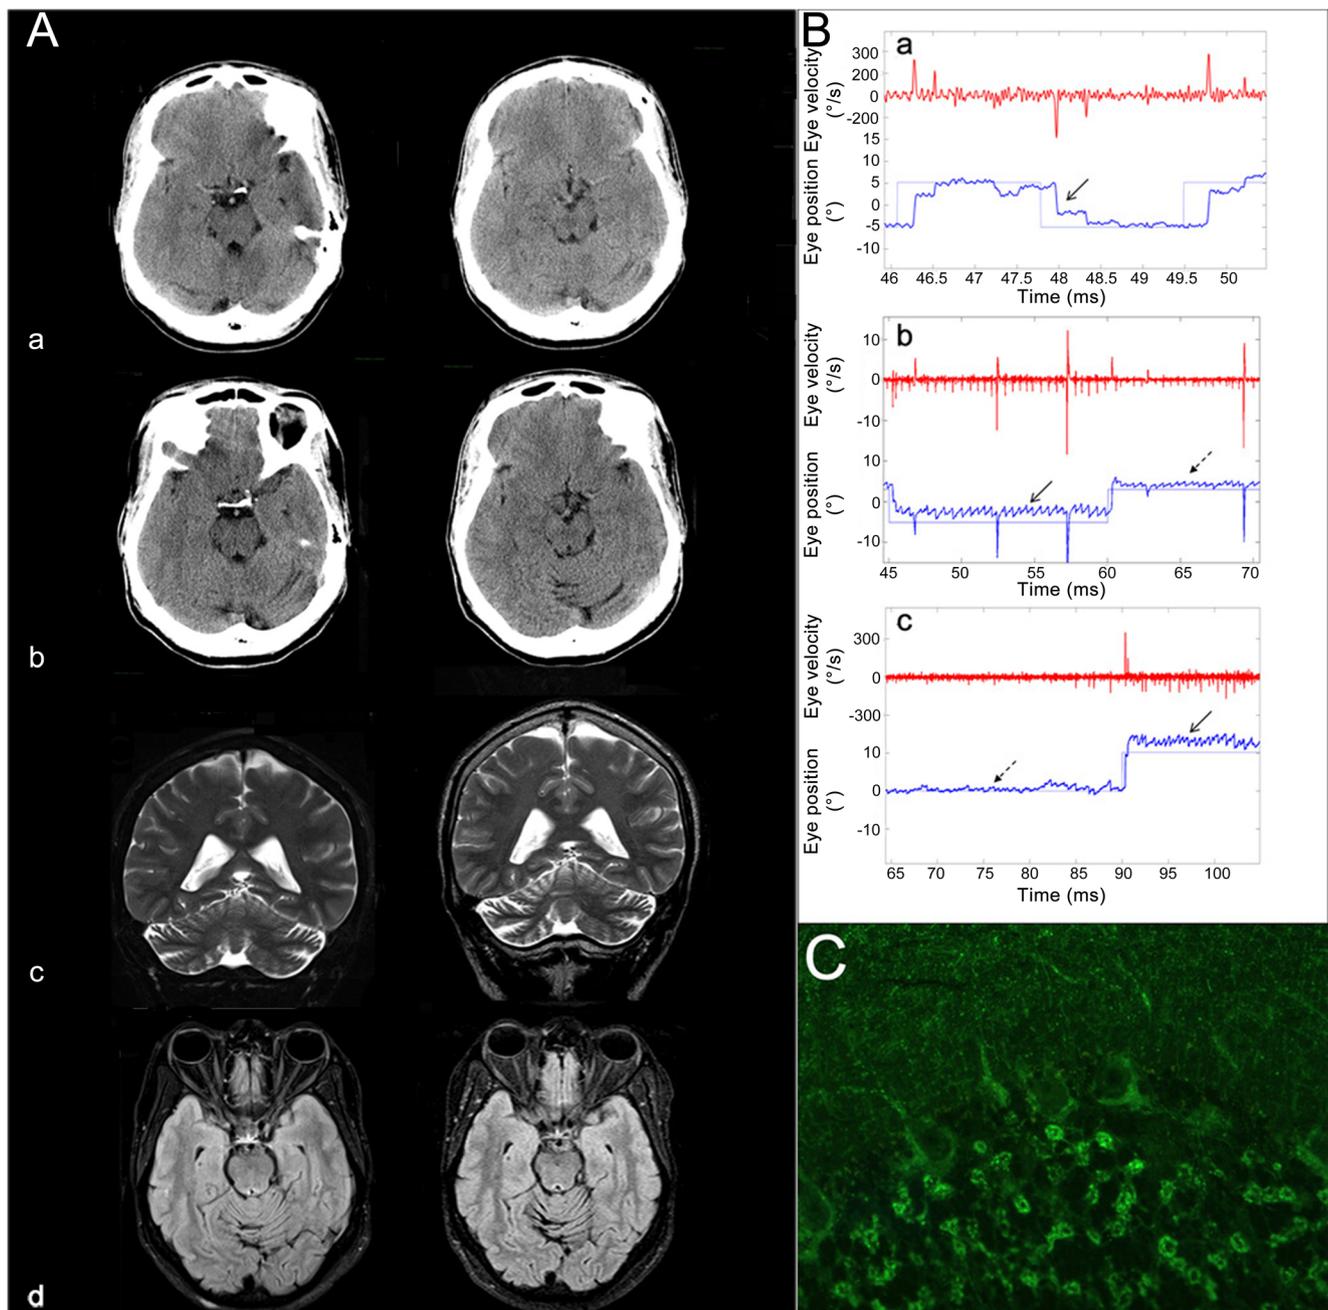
(A) Neuroradiological work-up. Consecutive computed tomography axial scans obtained in January 2011 (a) and August 2014 (b), T2-weighted coronal and fluid-attenuated inversion-recovery axial magnetic resonance images obtained in August 2014 (c) and January 2017 (d) show clear-cut development of cerebellar hemispheres atrophy, mainly in the right side, with relative sparing of the vermis. (B) Eye-movement recording: horizontal saccadic eye movement recording; central eye position (0° amplitude) and rightward displacement (10°) are shown (a). Saccades are hypometric and followed by a corrective saccade both toward the eccentric position (dotted black arrow) and to the center (black arrow). Fixation task; on the downward gaze
